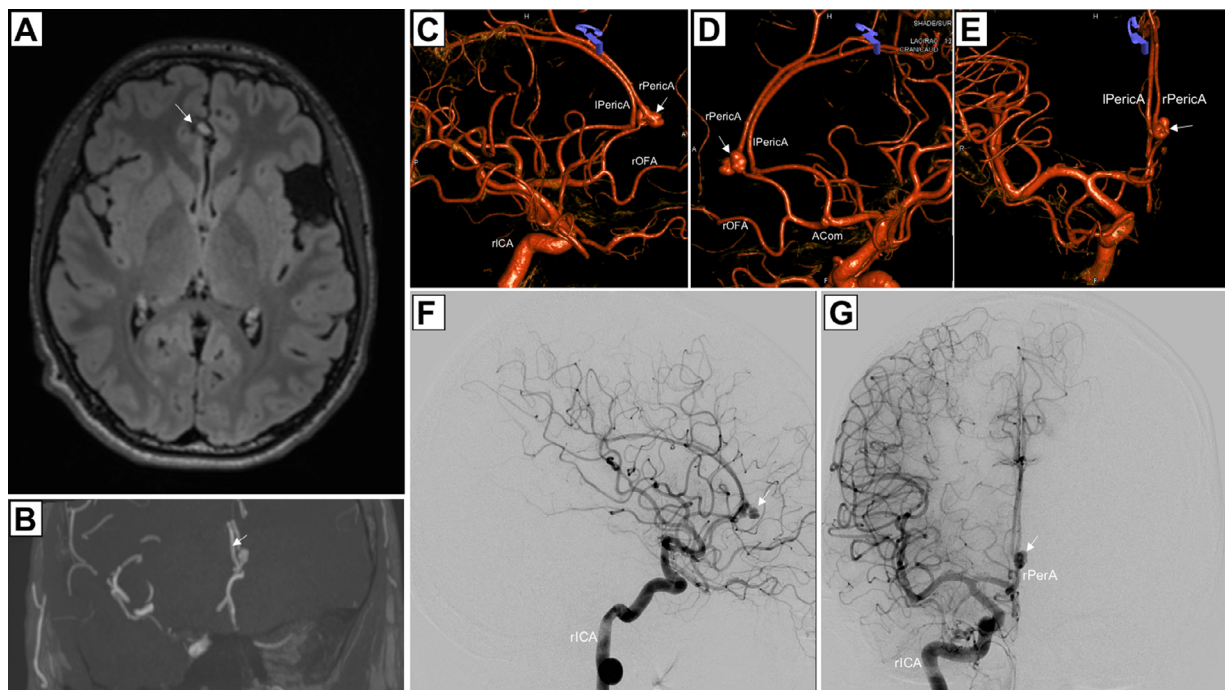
Case 2: Axial FLAIR-weighted MRI shows a partially thrombosed aneurysm (arrow) with hemosiderin deposit in the anterior interhemispheric fissure (IF) (A). Coronal TOF section displays the polylobulated, partially thrombosed 16 × 10 mm aneurysm (arrow) of the right dACA (B). DSA shows a partially thrombosed polylobulated aneurysm of the rPericA (lateral (C,D) and anterior-posterior (E) views of color coded DSA after right carotid artery injection). There are two A2 segments visible through injection of the rICA (DSA): one A2-segment gives origin to the right orbitofrontal artery (rOFA) and continues into the rPericA harboring the aneurysm. Another A2-segment continues directly in the lPericA. Lateral (F) and anterior-posterior (G) view of non-color coded DSA. The partially thrombosed polylobulated aneurysm of the rPericA is marked with an arrow. CMA = callosomarginal artery; dACA = distal anterior cerebral artery, ICA = internal carotid artery; OFA = orbitofrontal artery; l=left; PericA = pericallosal artery; r = right.
